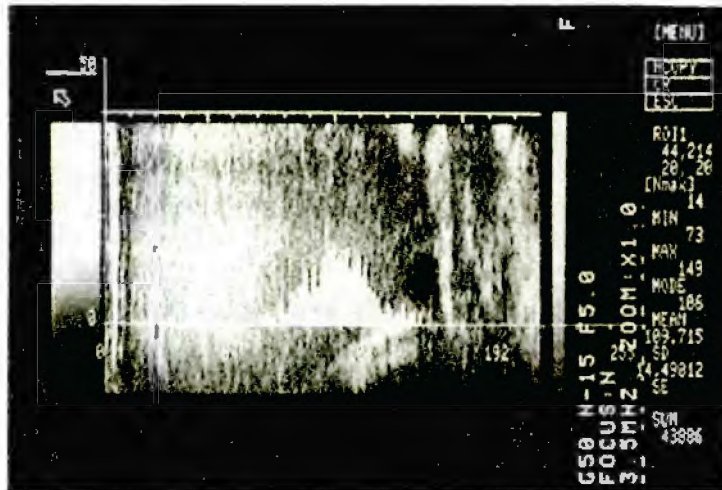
Echo histogram of hepatic ultrasonogram.
